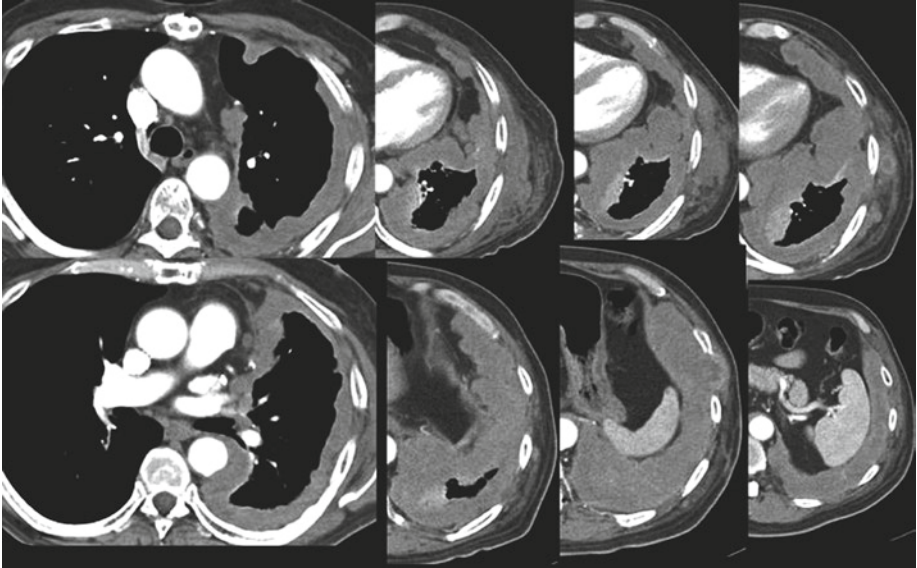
Serial contrast-enhanced axial CT images showing later presentation of epithelial mesothelioma, confined to the left hemithorax, this patient underwent successful extrapleural pneumonectomy
